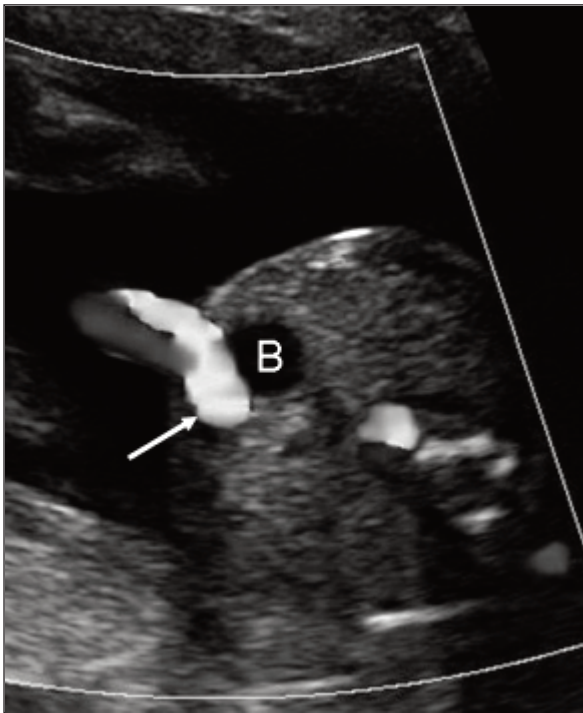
Color Doppler ultrasound confirms a single umbilical artery (arrow) coursing around the urinary bladder (B).
